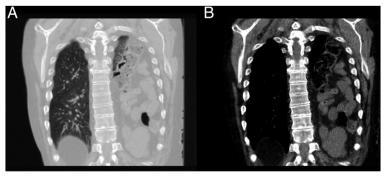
CT image of the thorax showing an enormously left-sided diaphragmatic hernia with almost the entire small intestine localised in the left hemithorax ((A) lung window; (B) chest—abdominal window).
